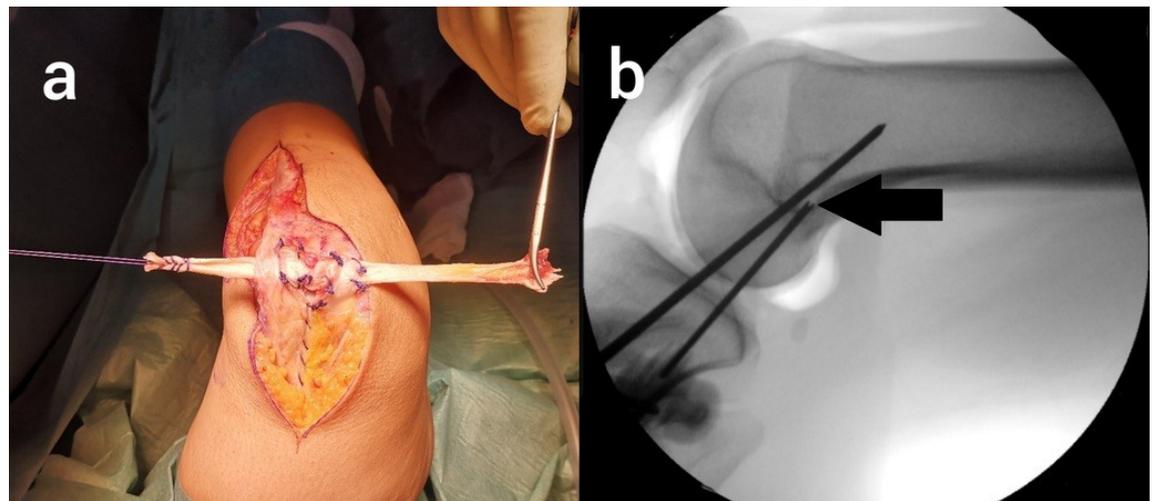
a.) Strips sutured to the lateral and medial patellar retinacula. b.) Intraoperative radiograph showing the insertion points of the LPFL (arrow). K-wire for MPFL reconstruction already inserted.
